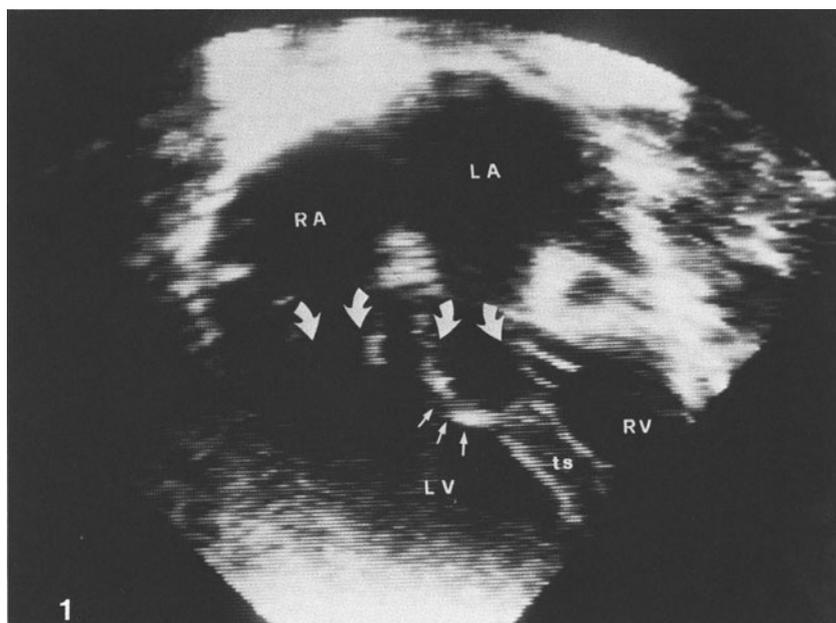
Apical four-chamber view in a patient with double-inlet left ventricle, left-sided rudimentary right ventricle, straddling, and moderate stenosis of the left AV valve. (RA, right atrium; LA, left atrium; LV, left ventricle; RV, right ventricle; and ts, trabecular septum).
